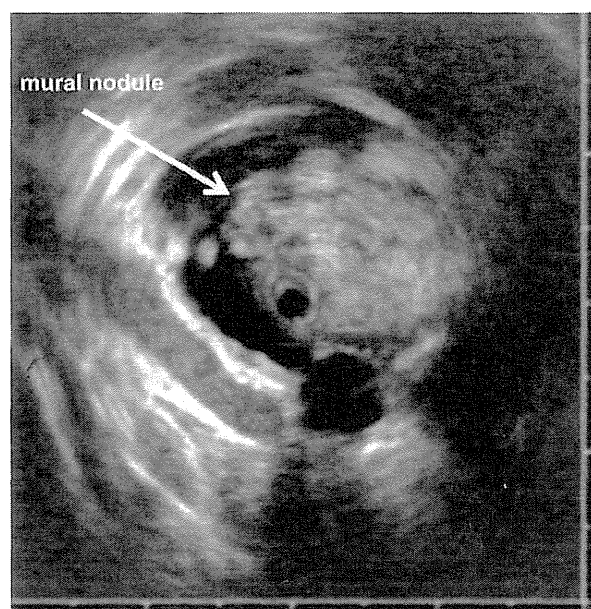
Intraductal ultrasonogram demonstrating a 25-mm mural nodule in the MPD.
